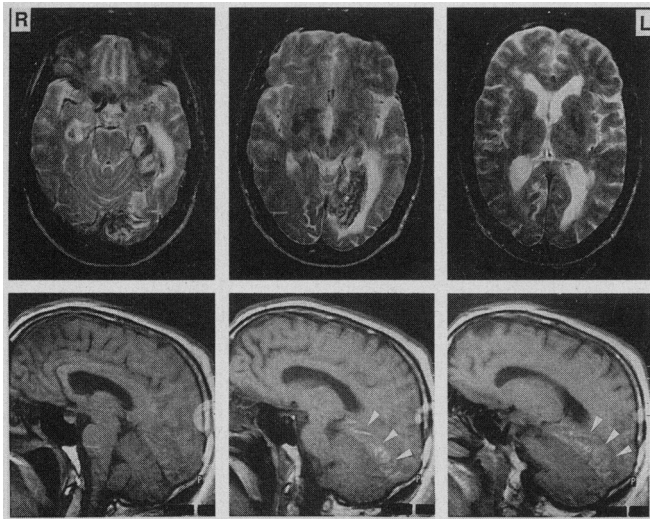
Magnetic resonance imaging of the brain. Top, Horizontal sections (TR 2000, TE 100, gadolinium enhanced) showing infarcts of the hippocampal area bilaterally. The lesion on the left side is much larger and involves the inferior temporal and occipital lobe. The medial temporo-occipital junction is spared; bottom, sagittal sections (TR 600, TE 15) of the left hemisphere. The most medial section shows no involvement of the medial temporo-occipital junction. More laterally, the infarct involves the inferior posterior temporal and inferior occipital lobe (arrows).
